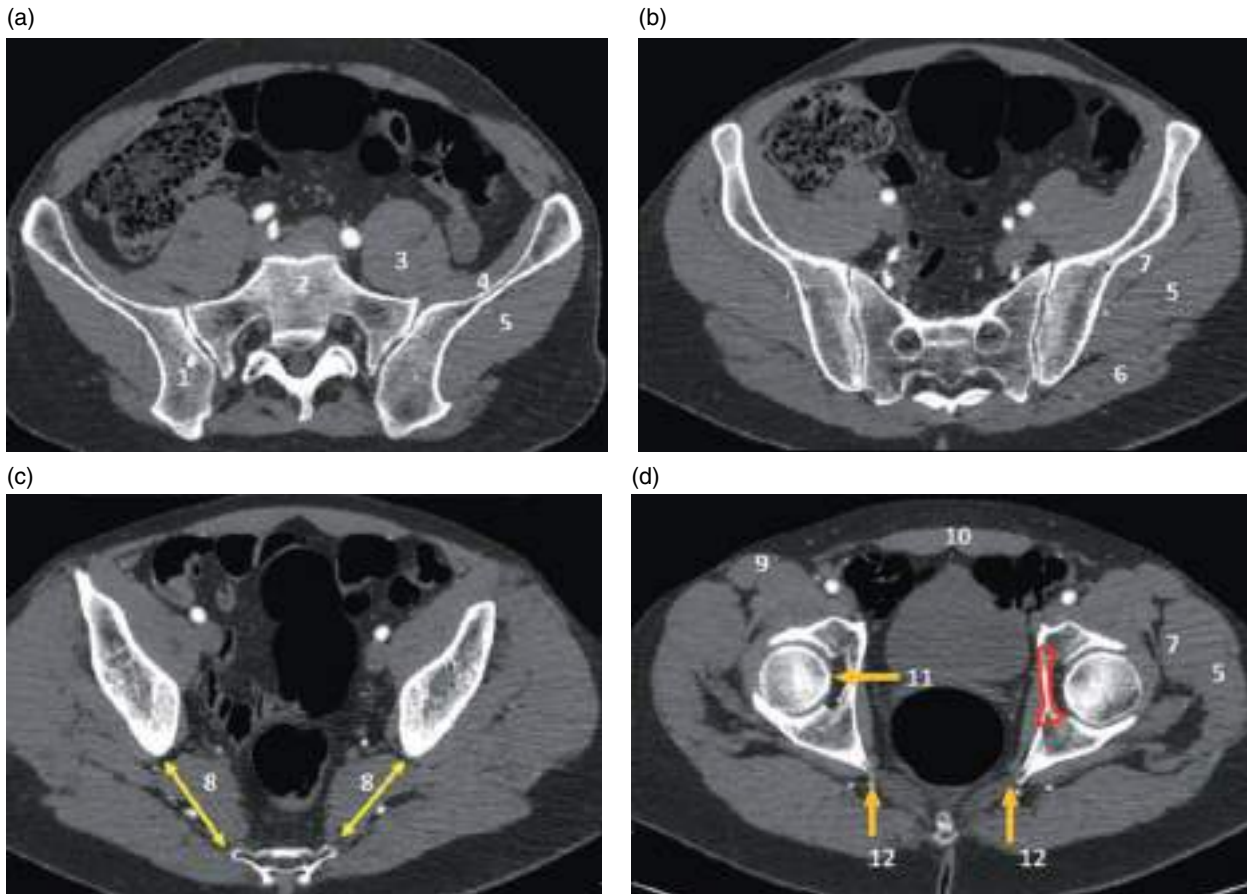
Axial CT images of the upper pelvis showing successive slices from cranial (a) to caudal (d). 1, ilium; 2, sacrum; 3, psoas muscle; 4, iliacus muscle; 5, gluteus medius muscle; 6, gluteus maximus muscle; 7, gluteus minimus muscle; 8, piriformis muscle; 9, sartorius muscle; 10, rectus abdominis muscle; 11, acetabulum; 12, ischial spine; red area, quadrilateral plate; double yellow line, greater sciatic foramen.
